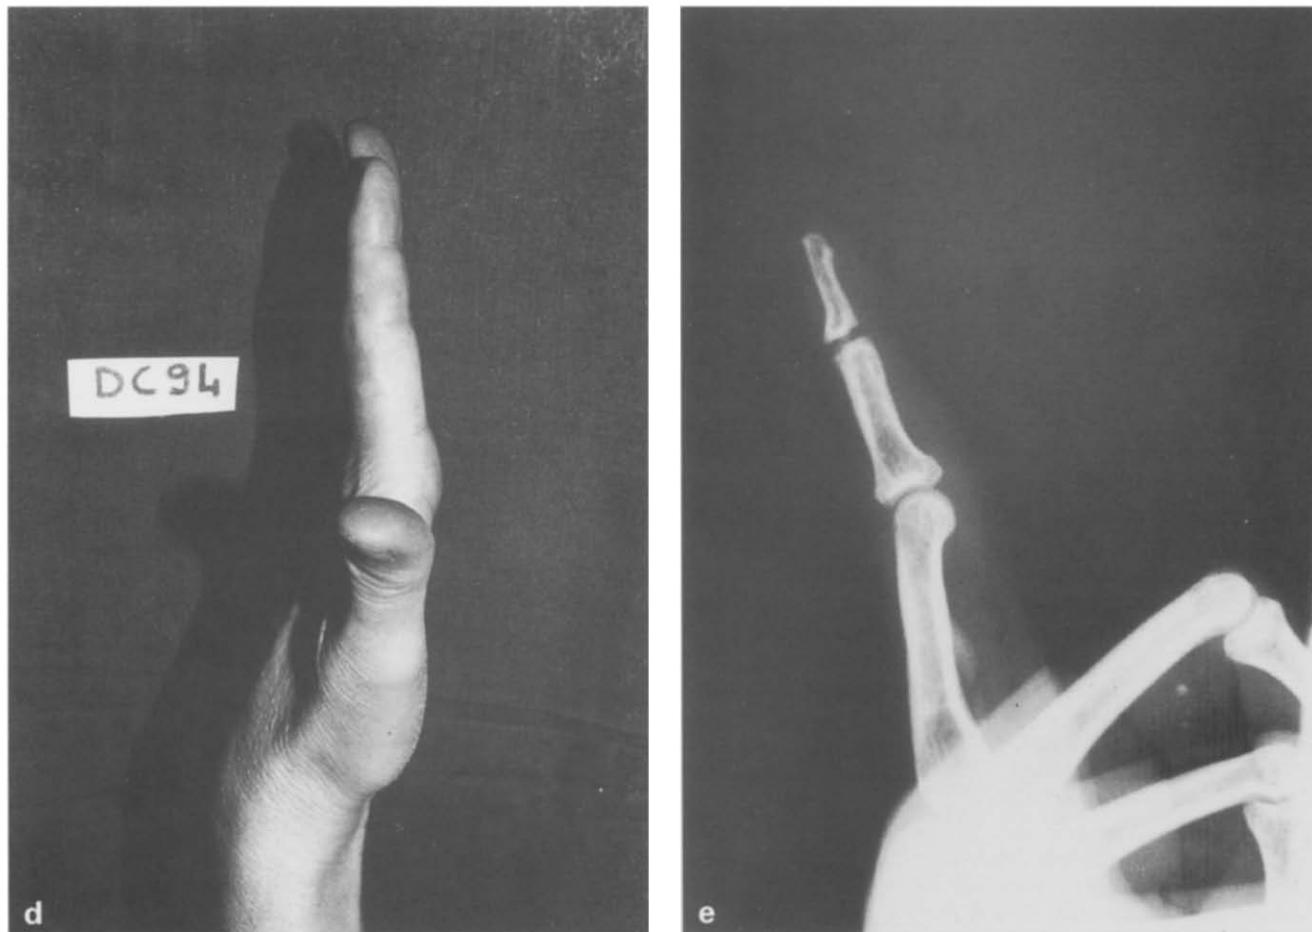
continued. (a) Pre-operative condition in a 25-year-old man, with an 80° flexion contracture of the PIP joint of the index finger of the left hand following a sprain and contusion 3 years earlier. (b) Pre-operative X-ray. (c and d) Results 6 months after the operation. (e) Post-operative X-ray.
